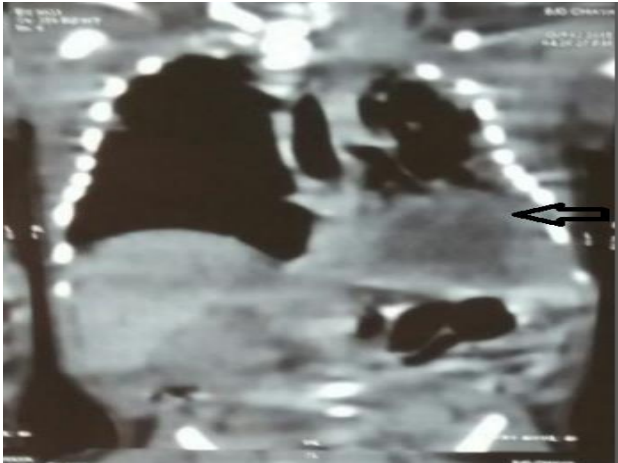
CT chest showing collapse of the left lower lobe with mediastinal shift.
